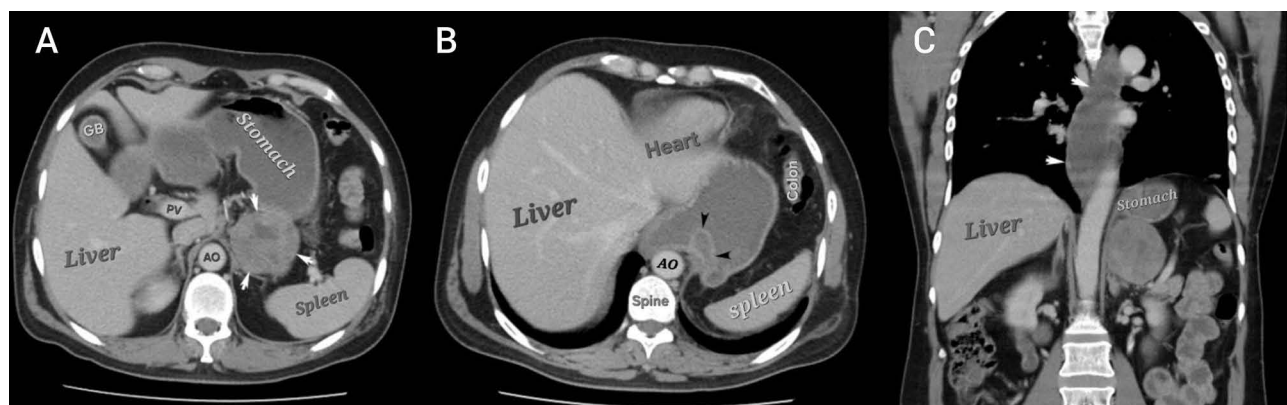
Postoperative follow-up contrast-enhanced CT scan (August 10, 2025). (A) Axial CT demonstrating a soft-tissue lesion posterior to the stomach (6.2 × 6.0 cm) abutting and indenting the posterior gastric wall (arrows). (B) Axial CT showing focal wall thickening at the cardia of the stomach (arrowheads). (C) Coronal CT showing a fluid-distended esophagus without wall thickening (arrows); no evidence of hiatal hernia is noted.
